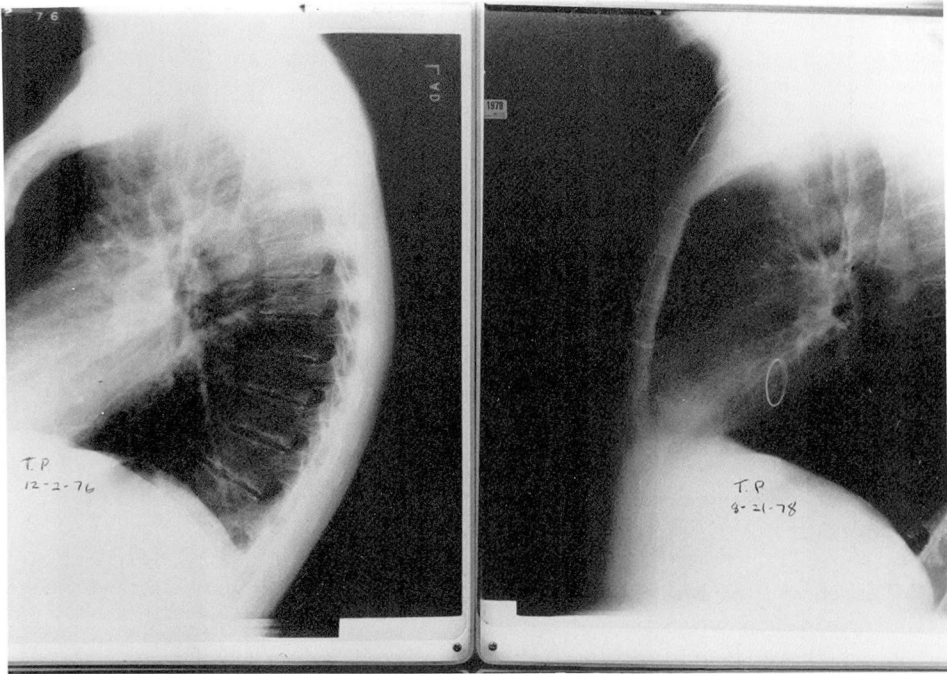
Lateral chest roentgenograms, December 2, 1976, show enlargement of the cardiac silhouette posteriorly in area of left atrium and a large right pulmonary artery. X-ray film, August 21, 1978, shows opaque annulus of prosthetic mitral valve and marked decrease in size of left atrium and right pulmonary artery.
